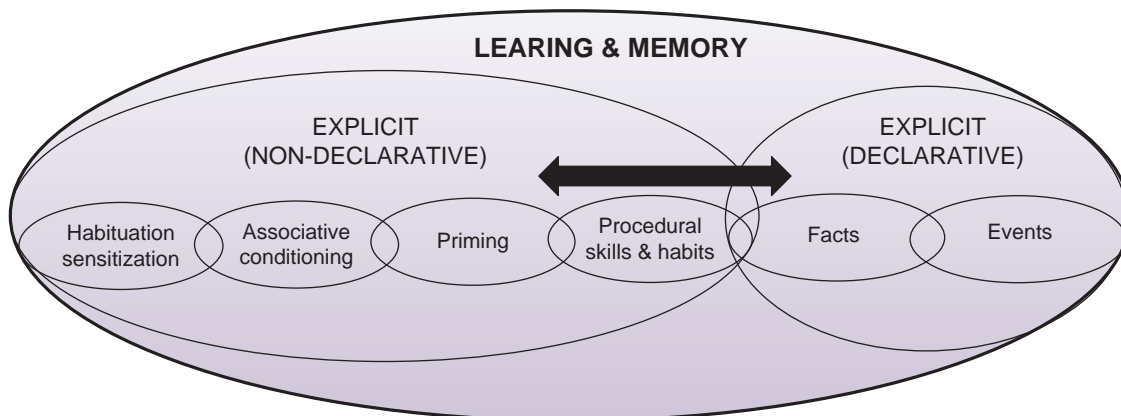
Learning is the process of acquiring information or skill while memory is the product of the learning process. Traditionally, the learning process has been described as having two separate domains: explicit (or declarative) learning, which is primarily involved in acquisition of knowledge about facts and events, and implicit or nondeclarative learning. Much of motor learning falls into the category of procedural implicit learning, or the mastery of skills and habits. Recent research evidence using functional magnetic resonance imaging suggests that there are interactions between explicit and implicit processes (arrow) regardless of whether the focus is on fact or movement.
